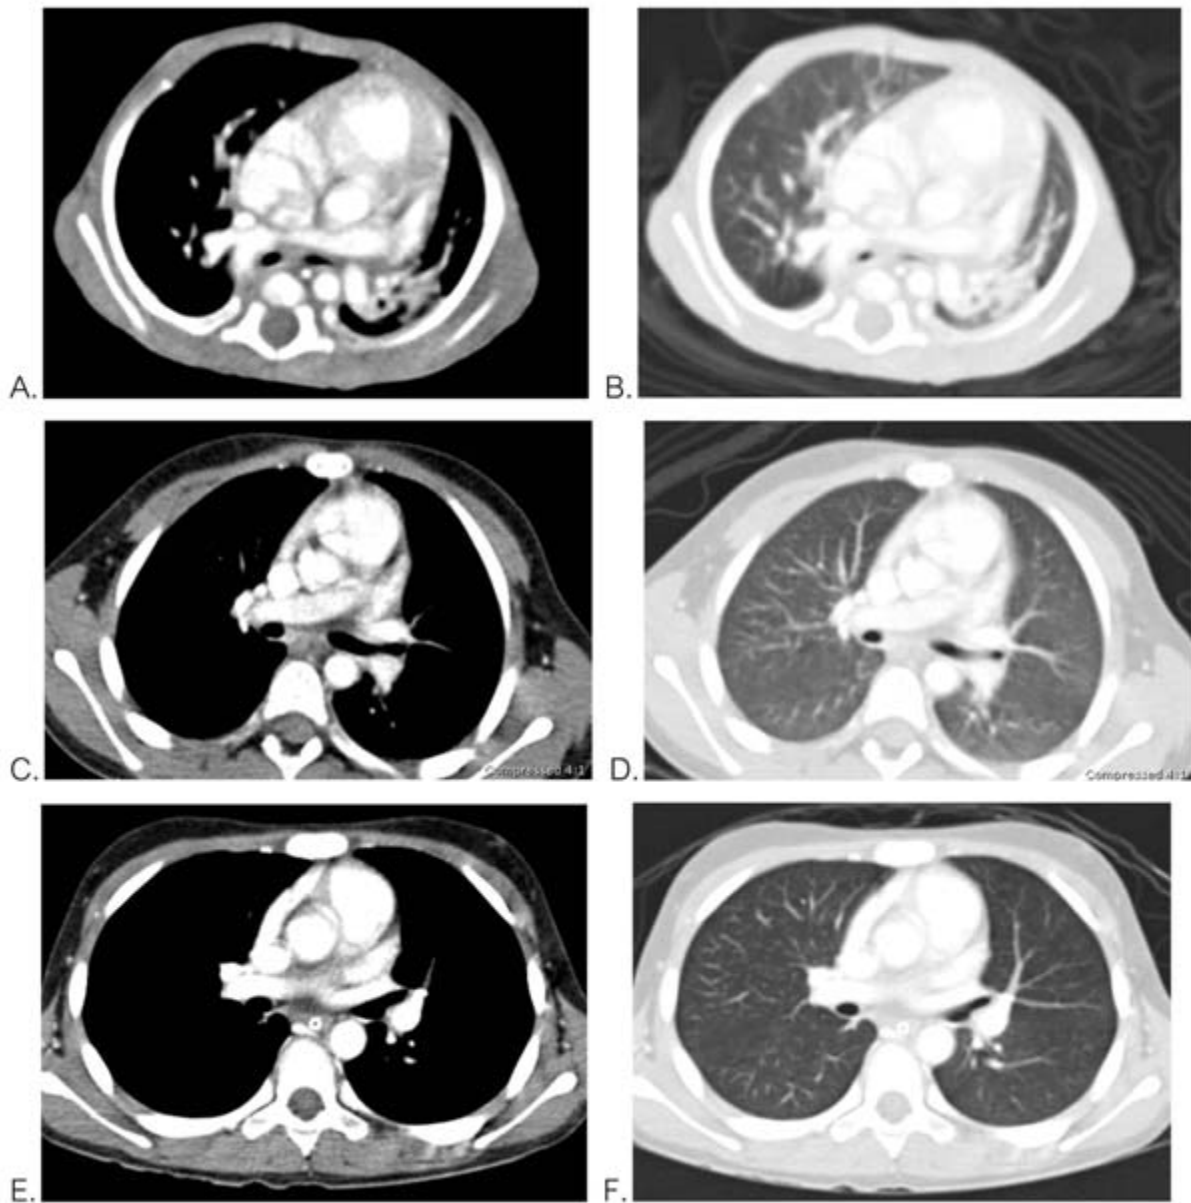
Chest CT at mediastinal window and lung window
